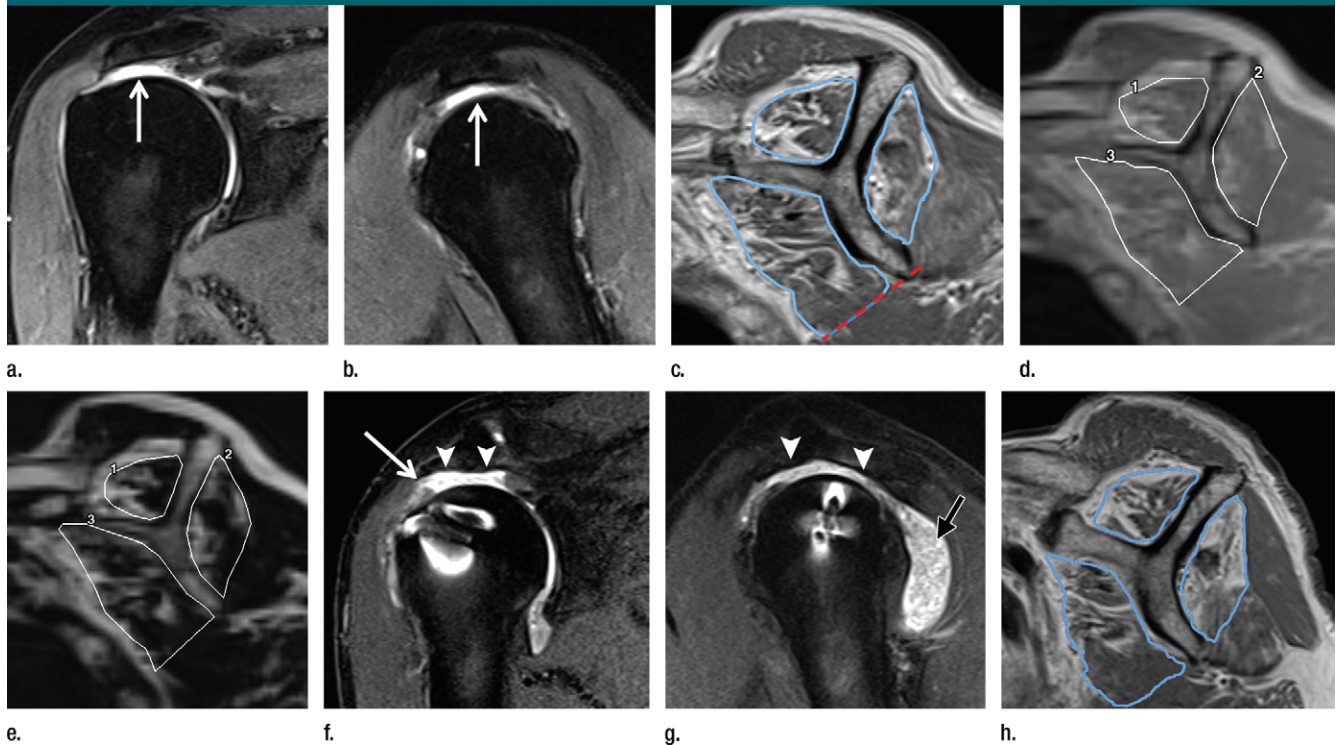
Images in 74-year-old man with massive rotator cuff tear. (a, b) Preoperative MR imaging showed discontinuity of the supraspinatus and infraspinatus tendons and fluid retention in the subacromial bursa (arrow) on oblique (a) coronal and (b) sagittal fat-saturated proton density-weighted images. (c) Oblique sagittal proton density-weighted MR image shows muscle regions and segmented areas (blue lines). Red dashed line = caudal boundary of the subscapularis muscle, defined as a horizontal line passing through the tip of the scapula. These findings are compatible with a modified-Goutallier scale stage 2 tear. (d, e) Measurements of signal intensity within regions of interest (ROIs) over the supraspinatus, infraspinatus, and subscapularis muscles were performed on oblique sagittal images on (d) an in-phase image and on (e) a fat image acquired with the two-point Dixon sequence. Each signal intensity value was represented as $S(\text{In})$ and $S(\text{Fat})$, and we calculated the fat fraction in each rotator cuff muscle with the formula $S(\text{Fat})/S(\text{In})$. Fat fractions were 0.494, 0.386, and 0.246 in the supraspinatus, infraspinatus, and subscapularis muscles, respectively. (f, g) Postoperative MR imaging shows re-tear of the supraspinatus and infraspinatus tendons and fluid retention in the subacromial bursa (arrowheads) on oblique (f) coronal and (g) sagittal fat-saturated proton density-weighted images. There is synovial proliferation, which is seen as intermediate signal intensity (arrow in g) and an increase in joint fluid. It indicates chronic synovitis. The re-tear point (arrow in f) is proximal from the footprint of the humeral head, in which the suture anchors were placed. (h) Postoperative oblique sagittal proton density-weighted MR image shows the progress of fatty degeneration within the infraspinatus muscle. In contrast, we cannot confirm definite changes of fatty degeneration within the supraspinatus and subscapularis muscles qualitatively. Fat fractions were 0.571, 0.593, and 0.266 in the supraspinatus, infraspinatus, and subscapularis muscles, respectively.
